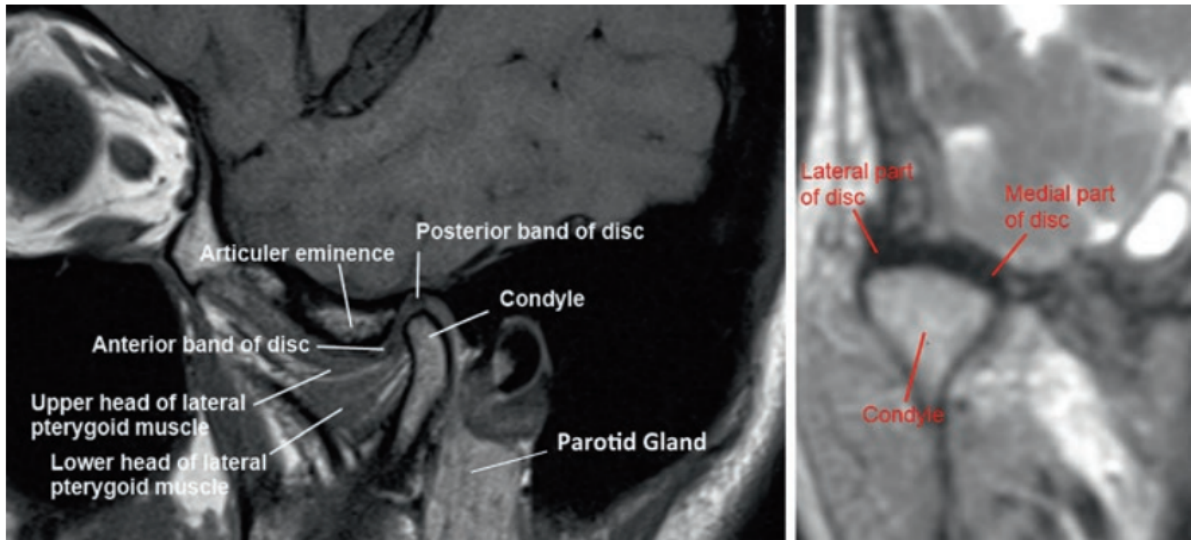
MRI image of diseased TMJ. Sagittal and coronal MR images showing the anatomical landmarks of TMJ (Rozylo-Kalinowska & Orhan, 2019)
